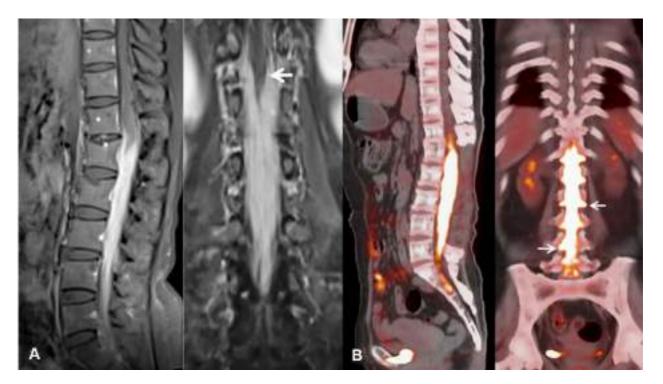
Figure I (A) Gadolinium enhanced sagittal and coronal TI MRI showing diffuse involvement of cauda equina with encasement of conus medullaris (arrows). (B) Staging whole-body 18F-FDG PET-CT coronal and sagittal views showing hypermetabolic mass in the cauda equina and lumbar nerve root sleeves (arrows).
